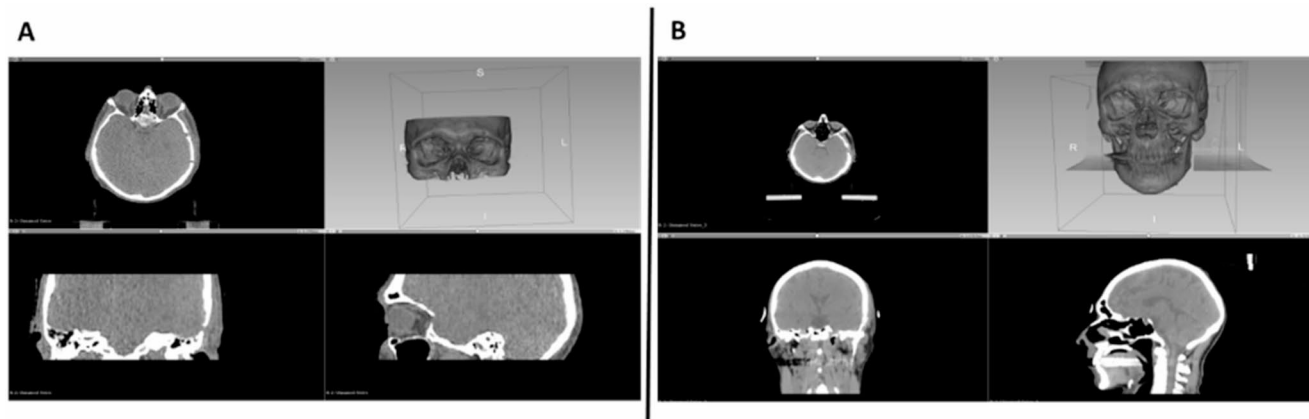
Example of alignment discrepancies in kV-CBCT image sets for follow-up scans (A) and the initial planning scan (B)
